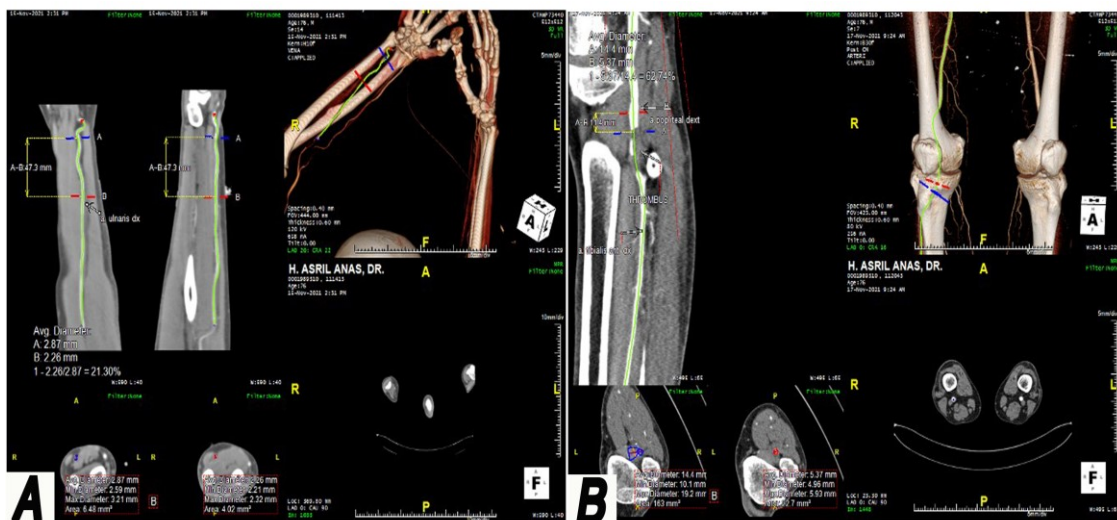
CT Angiography of leg.
